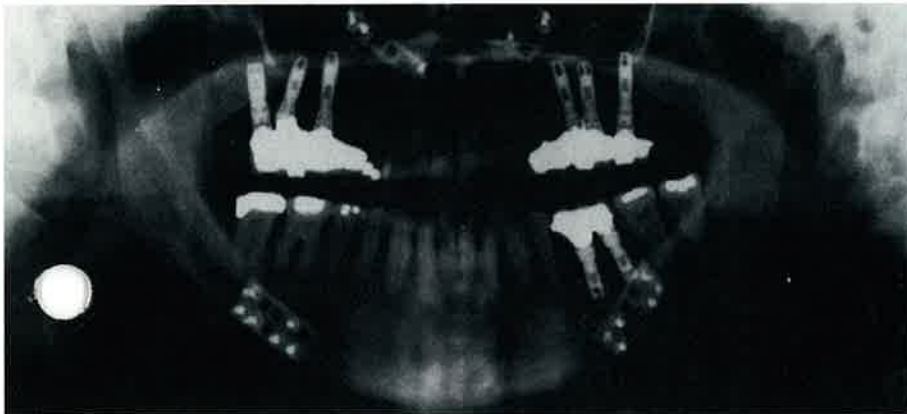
Postoperative panoramic radiograph following maxillary posterior osseointegration reconstruction and maxillary and mandibular orthognathic surgery.
